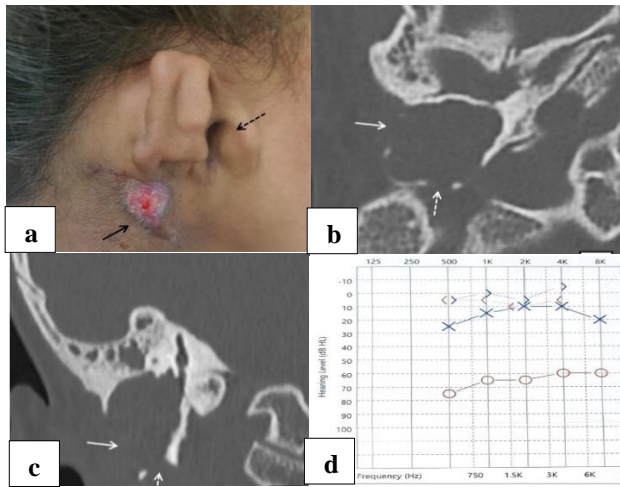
Clinico-radiological profile (a) picture showing infra-auricular abscess with skin ulceration (black arrow) along with atretic ear canal on the right side (black dotted arrow); (b) axial section of HRCT scan shows extensive soft tissue density destroying the bony landmarks of the middle ear cleft with breach in the mastoid cortex (white arrow) and in the sigmoid plate (white dotted arrow); (c) coronal section of HRCT scan showing extensive soft tissue density filling the middle ear cleft with destruction of the mastoid cortex (white arrow) and the mastoid tip (white dotted arrow); and (d) pure tone audiogram showing severe conductive hearing loss in right ear.
